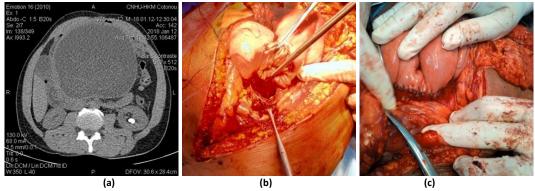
a: pseudocyst on CT-scan; b: empty pseudocyst before anastomosis; c: cysto-jejunostomy
